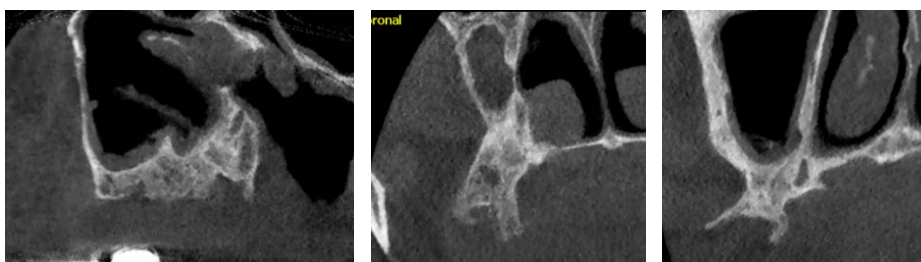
CBCT shows the anatomy of the maxillary tuberosity with the dense cortical bone formed by the pyramidal process of the palatine bone and the pterygoid process of the sphenoid bone
